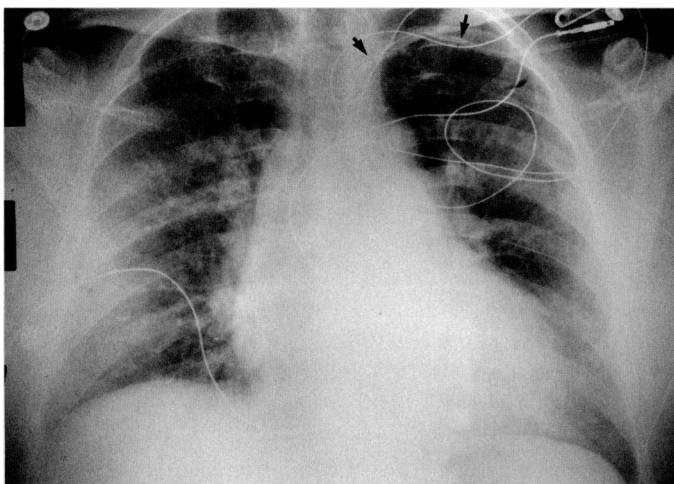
A portable chest radiograph demonstrates cardiomegaly with a prominent left ventricular configuration. There is pulmonary vascular congestion and interstitial edema. A central venous catheter is noted (*arrows*).
